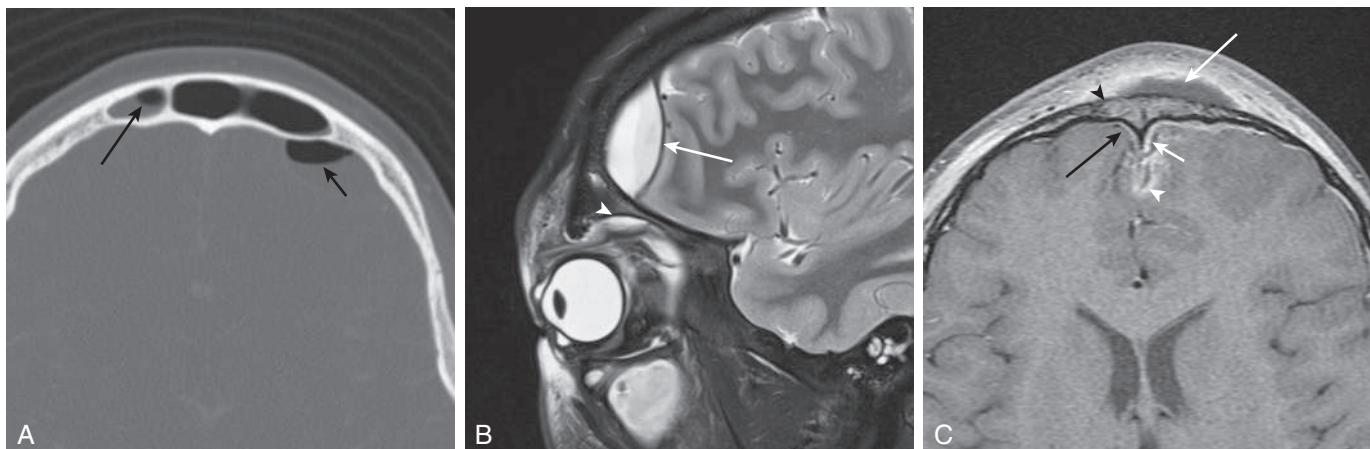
Acute complicated sinusitis. A, Frontal sinusitis and epidural abscess. Axial computed tomography image shows a frontal sinus air-fluid level (long arrow). There is also an intracranial air-fluid level associated with an epidural abscess (short arrow). B, Frontal sinusitis, epidural abscess, and orbital abscess. Sagittal fat-suppressed (FS) T2-weighted magnetic resonance (MR) image demonstrates a biconvex epidural abscess (arrow) containing a sediment level. There is also a small superior extraconal subperiosteal abscess (arrowhead). Periorbital STS is present, and there are secretions within the maxillary antrum. C, Pott puffy tumor, frontal osteomyelitis, and subdural empyema. Axial gadolinium-enhanced FS T1-weighted MR image shows frontal scalp swelling ventral to an elliptical low signal intensity, peripherally enhancing, frontal subperiosteal abscess (long white arrow). There is enhancement of the subjacent frontal bone, consistent with osteomyelitis (black arrowhead). There is also dural enhancement (black arrow) and a small left frontal interhemispheric subdural empyema (short white arrow) with subtle enhancement of the adjacent frontal leptomeninges and cortex caused by meningitis and cerebritis (white arrowhead). (From Walters MM, Robertson RL, eds. *Pediatric Radiology: The Requisites*, 4th ed. Philadelphia: Elsevier; 2017: Fig. 10.40.)
